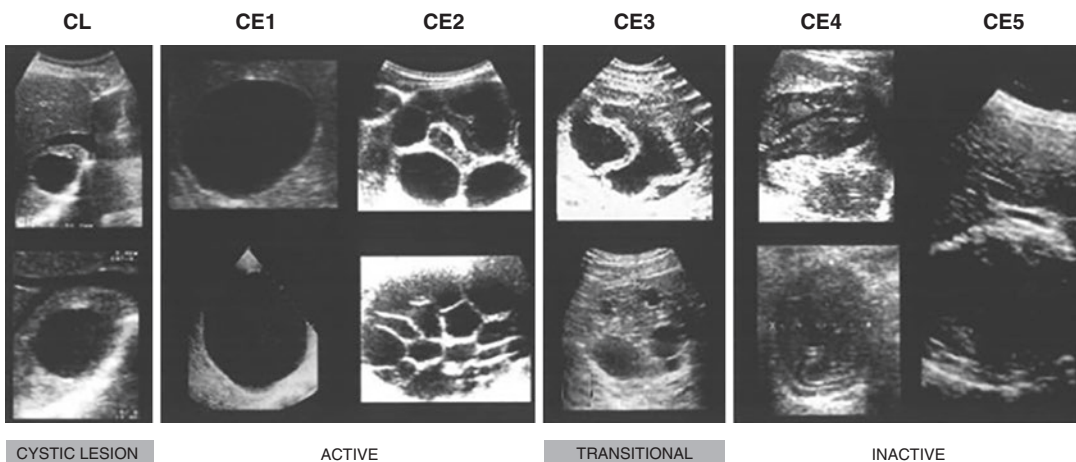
WHO cystic echinococcosis (CE) grading scale by ultrasound. The classification is intended to follow the natural history of CE and starts with undifferentiated simple cysts, as presumably hydatid cysts evolve from these structures. The first clinical group starts with cyst types CE 1 and 2 and such cysts are active, usually fertile containing viable organisms. CE type 3 are cysts
